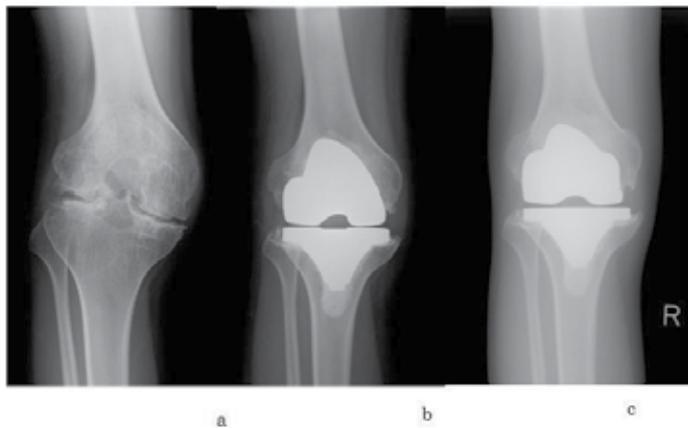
A 18-year-old hemophilia A patient without inhibitor. No virus infection. Severe hemophilic arthropathy of the right knee. His knee range of motion was improved at four years after surgery: extension was -30 degrees to 0 degrees and flexion was 90 degrees to 110 degrees. (a): pre-operative radiography; (b) at one month radiography (c) at four year radiography
